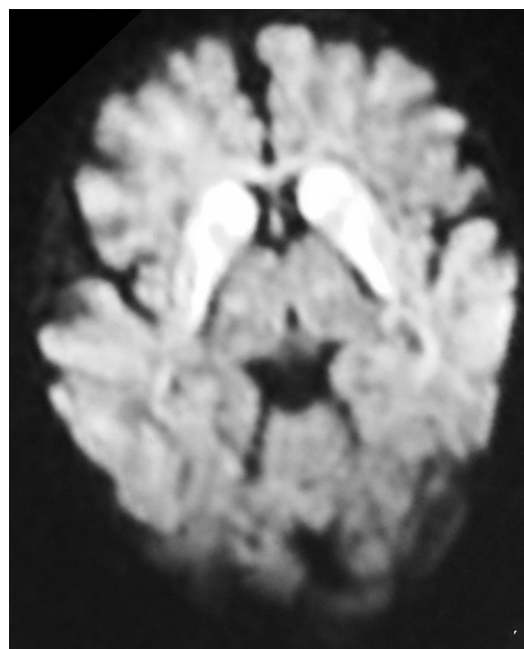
Diffusion weighed MR imaging showing bilateral symmetric bright signals in the regions of caudate and putamen.
